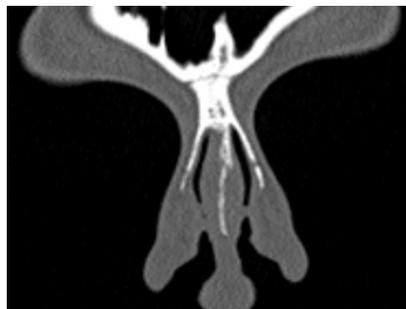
Coronal CT scan. Two years after the surgery: the normal anatomy of the NS.
